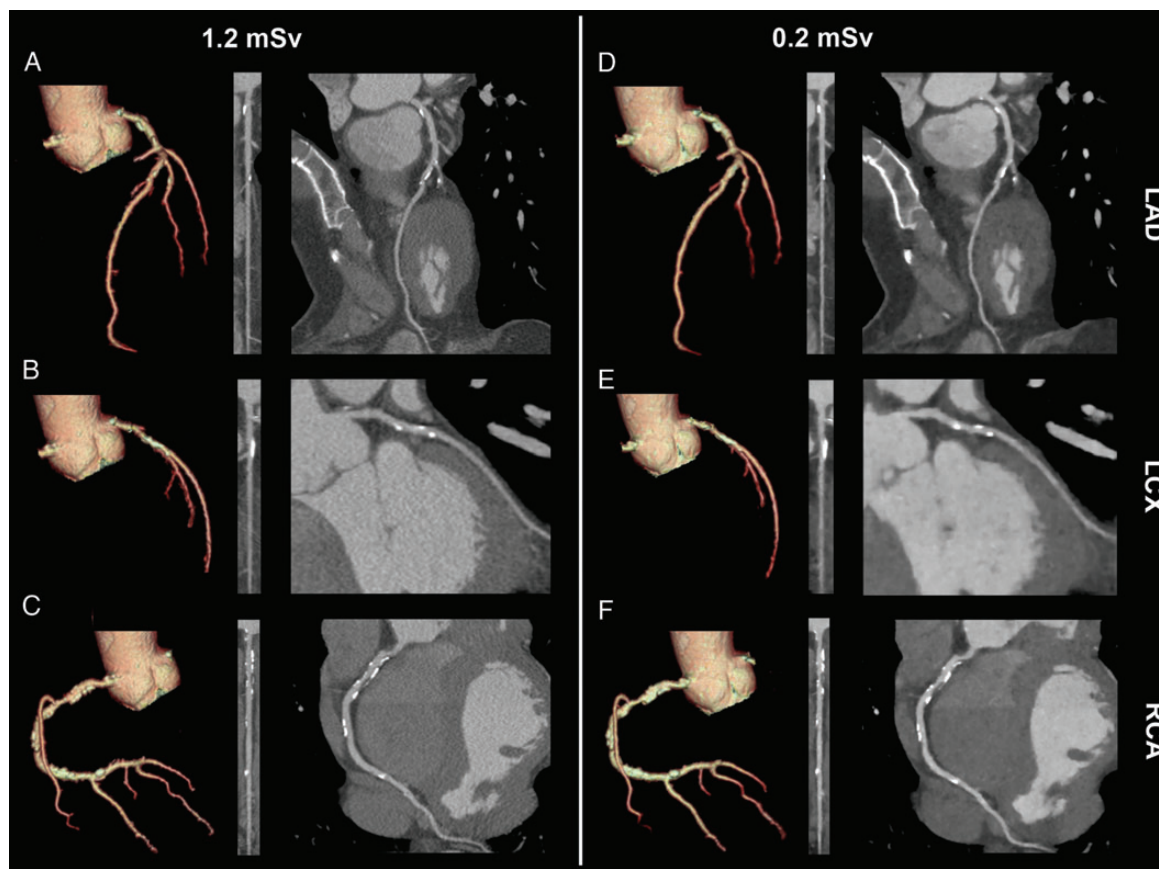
Three-dimensional volume rendered images and corresponding multiplanar and curved multiplanar images of a patient with calcifications in the left anterior descending (LAD), the left circumflex (LCX), and the right coronary artery (RCA) from standard (A–C) and ultra-low-dose (D–F) coronary computed tomography angiography of the same patient acquired with 1.2 and 0.2 mSv. Both ultra-low-dose and standard coronary computed tomography angiography revealed a 50% luminal narrowing in the RCA, which was confirmed by invasive coronary angiography.
